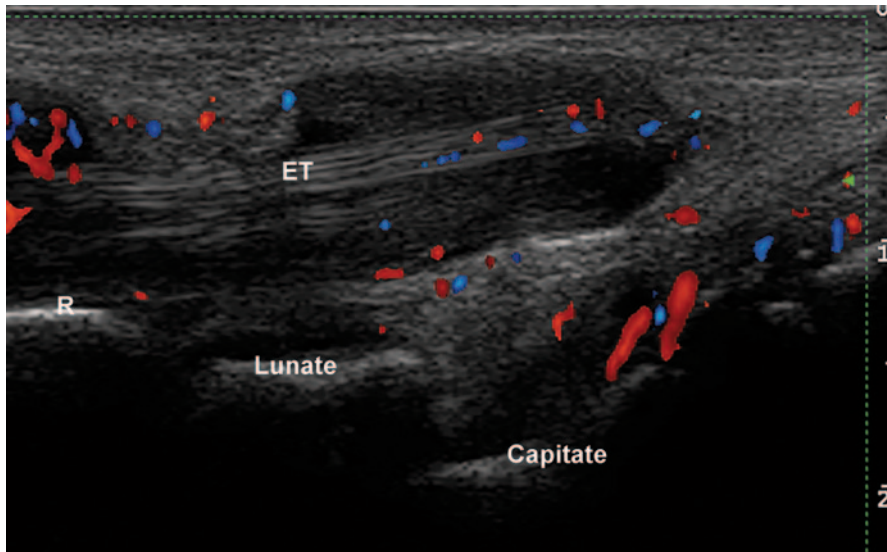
Longitudinal view of the dorsal side of carpal joints in a rheumatoid arthritis patient. Normal size of Doppler vessels in a rheumatoid arthritis patient. *ET* extensor tendon
